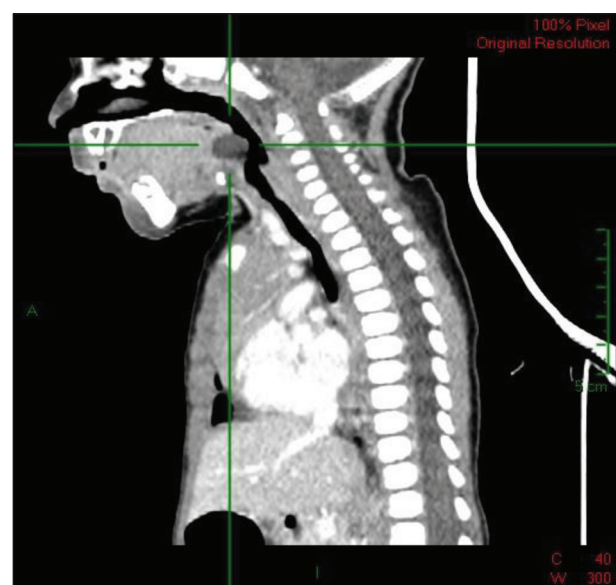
Sagittal computed tomography scan of neck with detected cystic formation at the base of tongue which narrow respiratory airway
